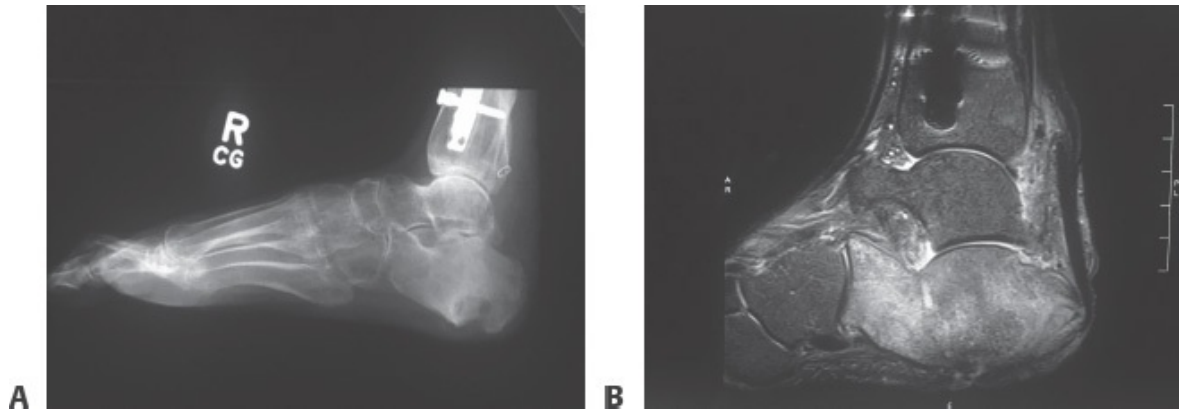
• A. Radiograph of the right foot demonstrating periosteal reaction of the calcaneus indicating osteomyelitis. B. Corresponding MRI of the right foot demonstrating the extent of calcaneus osteomyelitis.
